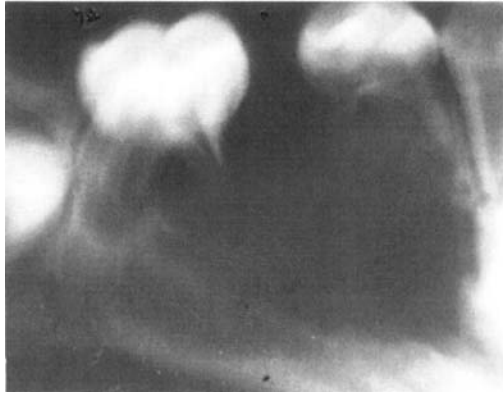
Two and a half-yr old boy with mandibular infantile fibrosarcoma. Preoperative radiograph showing displacement of tooth bud.
